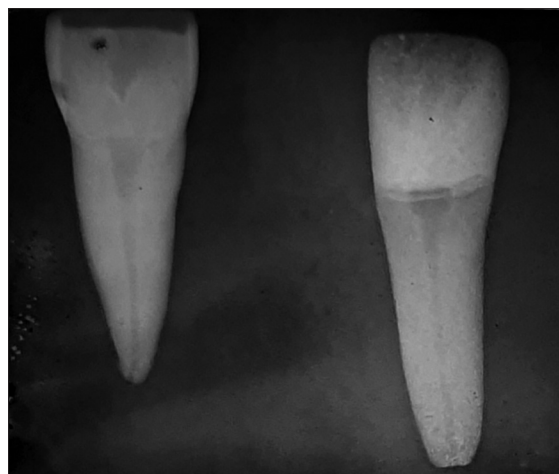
Maxillary central incisor radiograph.
